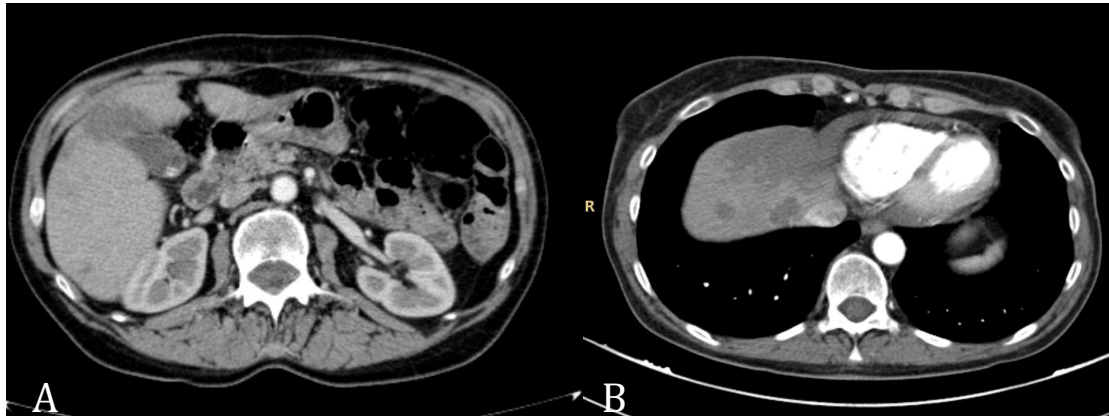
CT-scan A) At randomization, B) One month from randomization
